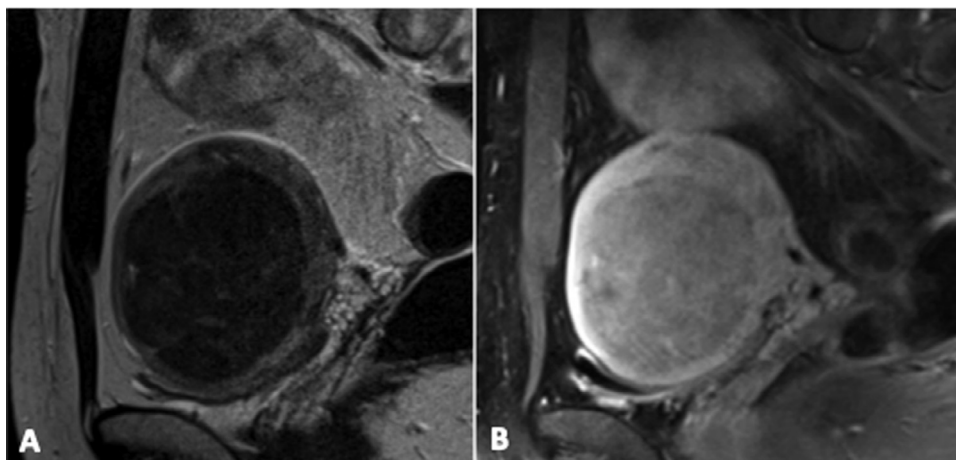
Pretreatment MRI images of an uterine fibroid suitable for percutaneous approach (A,B).
